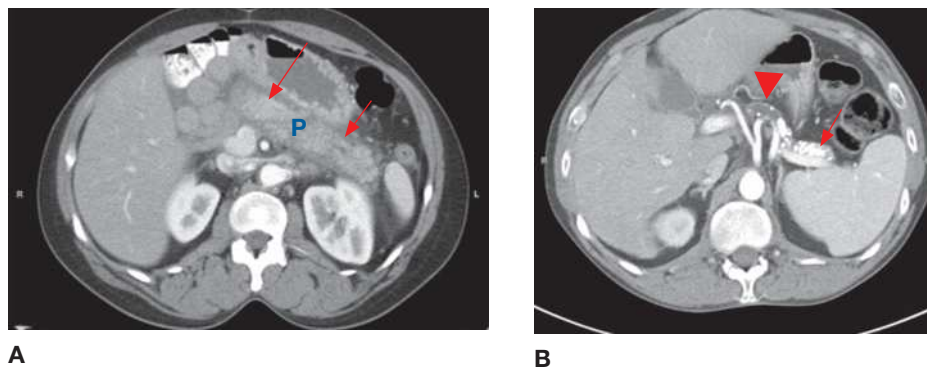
Pancreatitis. Transaxial contrast-enhanced CT images. (A) Uncomplicated acute pancreatitis. Peripancreatic fluid and fat stranding can be seen (arrows). P, pancreas. (B) Chronic pancreatitis. Note the dilated pancreatic duct (arrowhead) and pancreatic calcifications (arrow). (Reproduced with permission from USMLE-Rx.com.)
